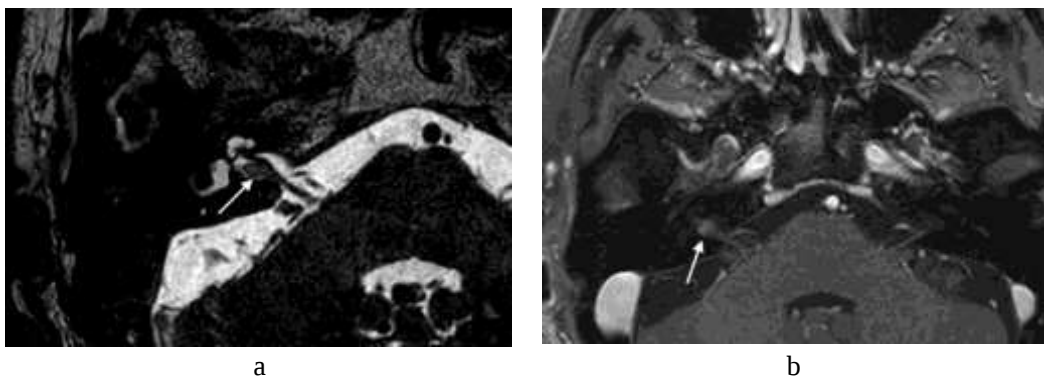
Lipochoristoma; axial CISS (a) and axial contrast-enhanced T1-weighted turbo spin echo sequence with fat saturation (b). A small lesion with fat-like signal on all pulse sequences is found (arrows) deep into the right IAC.
